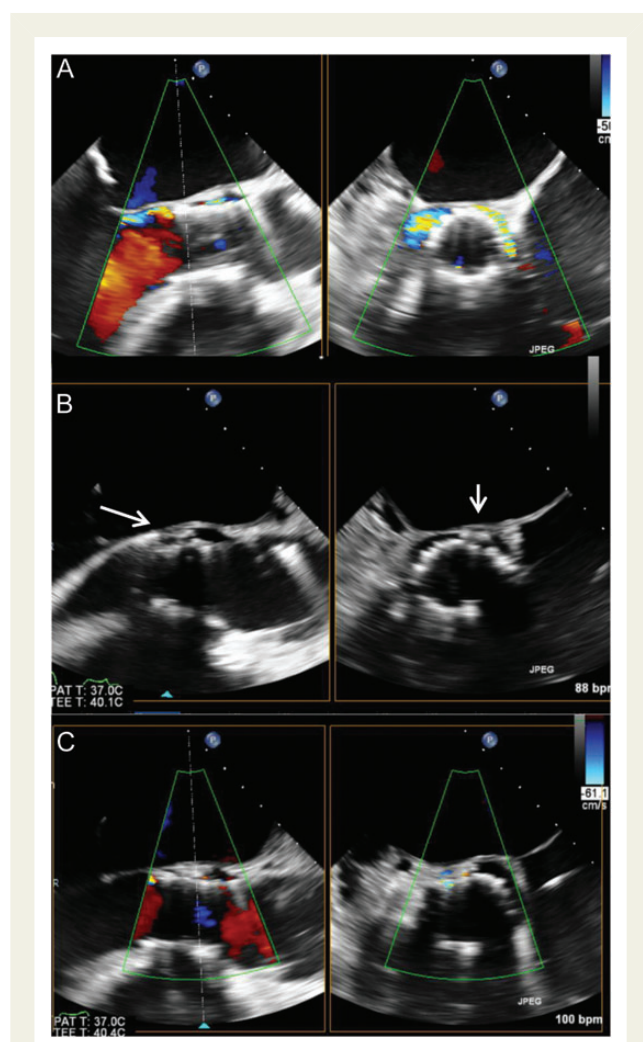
Treatment of significant paravalvular aortic regurgitation after transcatheter aortic valve implantation. Implantation of an AMPLATZER® Vascular Plug III closure device to seal a severe paravalvular aortic regurgitation as observed in the parasternal short-axis view with a circumferential extent >20% (A). The device is inserted between the native aortic root and the prosthetic frame (arrows) (B), resulting in significant reduction of the paravalvular regurgitant jet (C).
